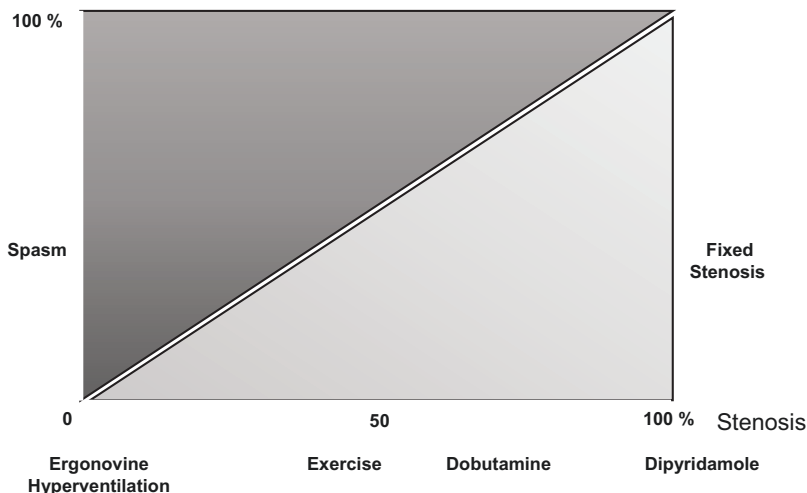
Conceptual allocation of the tests employed in combination with echocardiography to induce ischemia via coronary vasospasm (*left*), coronary stenosis (*right*), or both mechanisms
